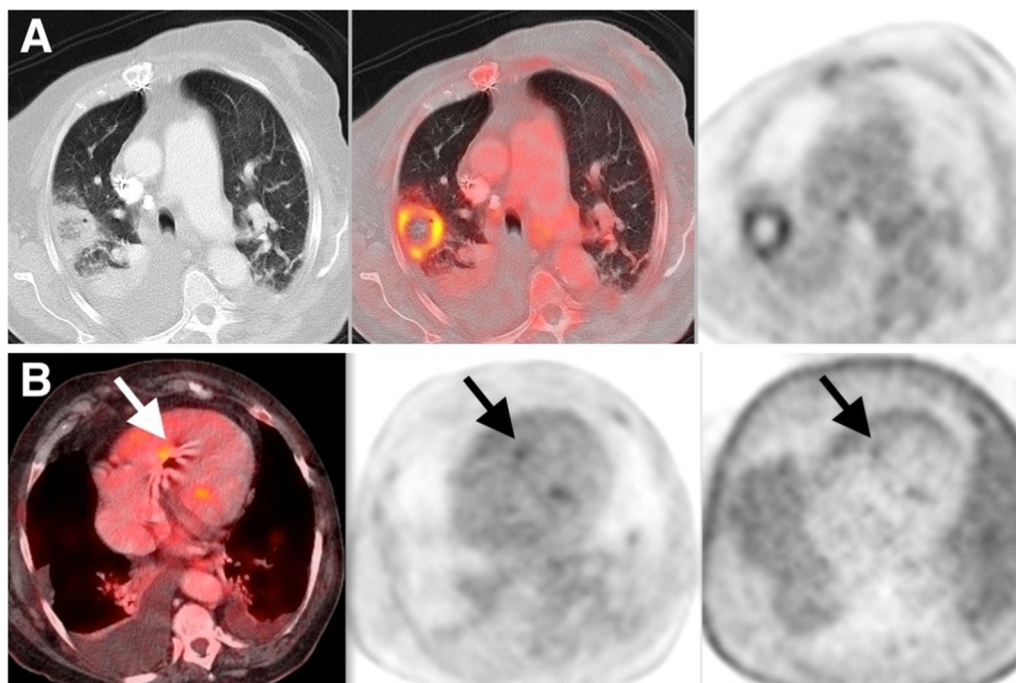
Pulmonary embolism documented by PET/CT in a patient with CIED-IE. (A) ^{18}F -FDG PET/CT axial views of a patient with pacemaker IE due to *S. aureus* showing a subpleural nodular lung opacity in the right upper lobe with central low attenuation region and intense FDG uptake in its periphery suggestive of pulmonary embolism. Transesophageal echocardiography showed a 1 cm vegetation attached to the lead. (B) Axial PET/CT view showing fusion (left), PET attenuation correction images (middle) and PET non attenuation correction images (right) showing focal FDG intracardiac pacemaker lead uptake (arrows). CIED, cardiac implantable electronic device; IE, infective endocarditis.
